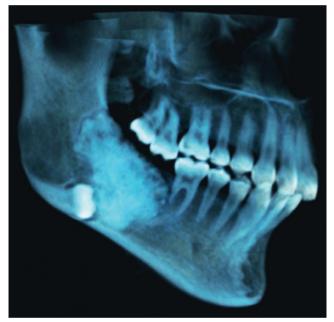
Preoperative tridimensional cone beam computed tomography image
